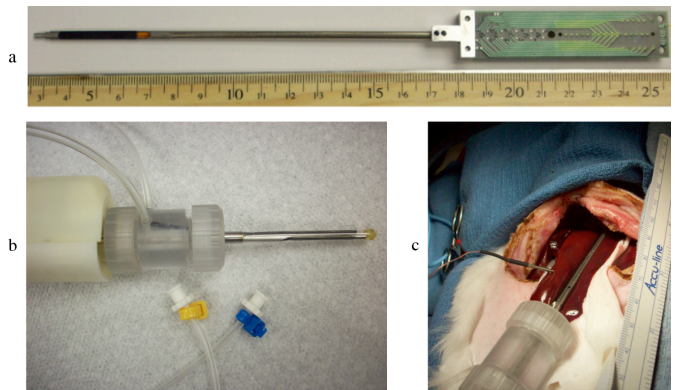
Miniaturized image-ablate ultrasound probe. (a) THX4A array device showing 32 element, 20 mm aperture, 8-gauge needle housing, and interconnect board. (b) Assembled probe with handpiece, PET coupling balloon, and circulation connections. (c) Probe placed for ablation of rabbit liver *in vivo*.
